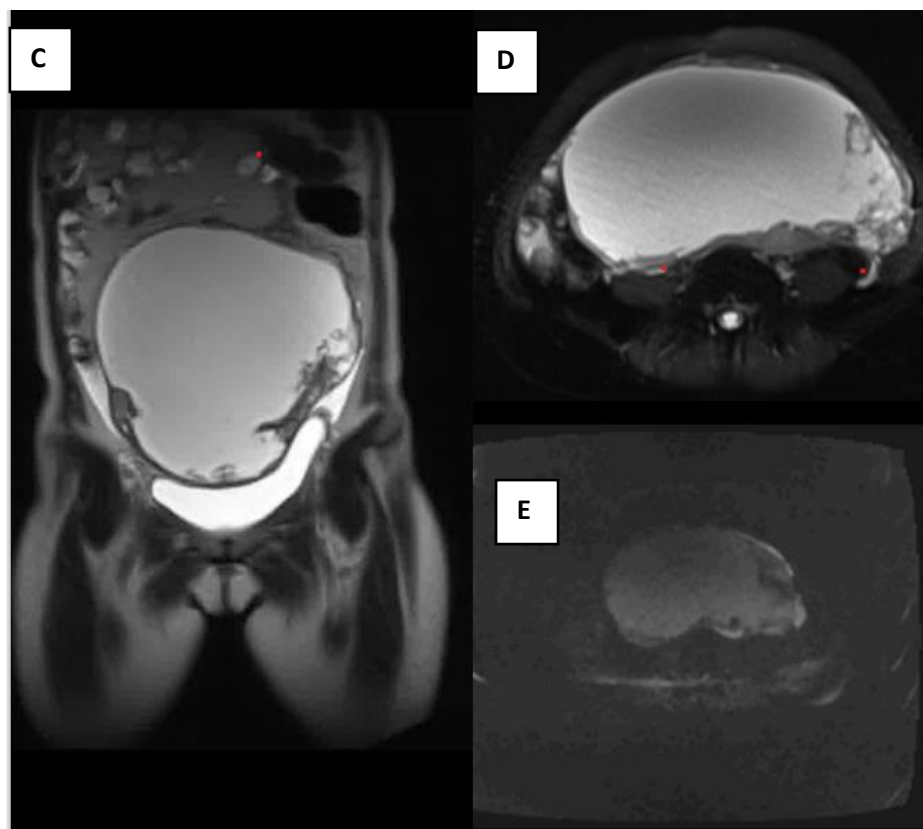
MRI images (c&d) showing right ovarian predominant cystic lesion with peripheral solid component that showing restricted diffusion on DWI(e), associated with mild ascites and restricted peritoneal nodules
